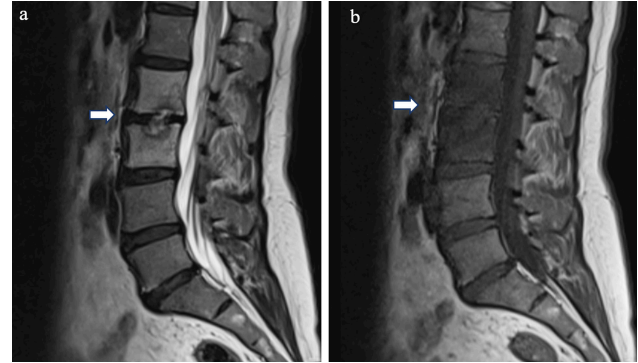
Lumbar magnetic resonance images from a 47-year-old woman with Brucellar L2-L3 spondylodiscitis. T2-weighted sagittal image shows hyperintense signal intensities in L2-L3 vertebral bodies and the intervertebral disc (white arrow) (a). T1-weighted sagittal image shows homogeneous hypointensity in L2-L3 vertebral bodies and the intervertebral disc (white arrow) (b).
